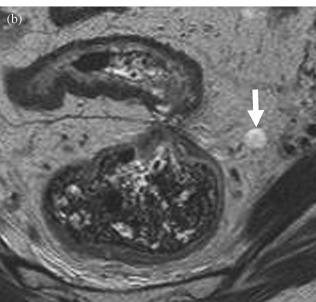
Mucinous change after chemoradiation treatment. (a) Pretreatment T2-weighted image showing a malignant stricture of the rectosigmoid with a heterogeneous lymph node in the left mesorectum (arrow). (b) After chemoradiation treatment, the node returns uniform high signal intensity, indicating mucinous change (arrow).
